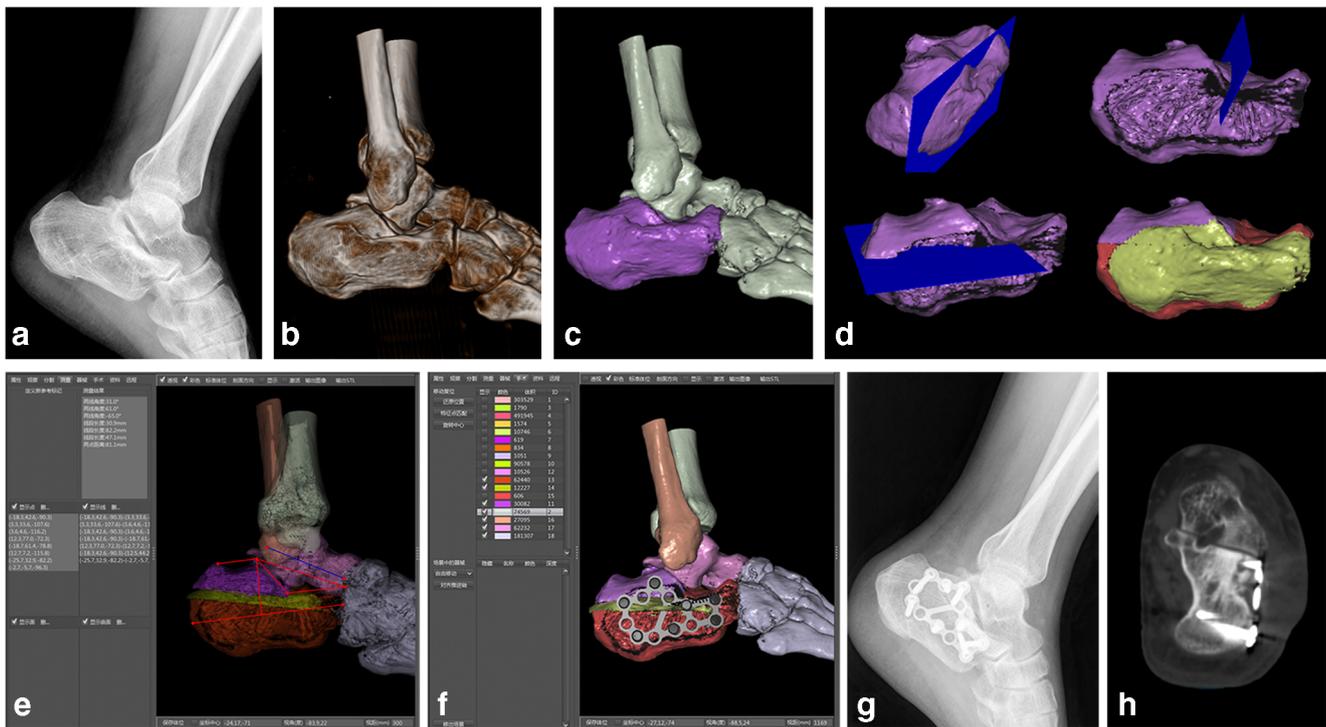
The computer-assisted pre-operative planning for the reconstruction of calcaneal thalamus for joint-preserving osteotomy. a The radiography showed that the calcaneal fracture malunion occurred in a 30-year-old female due to the conservative treatment one year ago. b The 3-D volume rendering image revealed the lateral wall blowout and the clear subtalar joint. c The shaded surface display image of the calcaneus was labeled by 3D interactive and automatic segmentation. d The plane cutting technique for virtual osteotomy.
